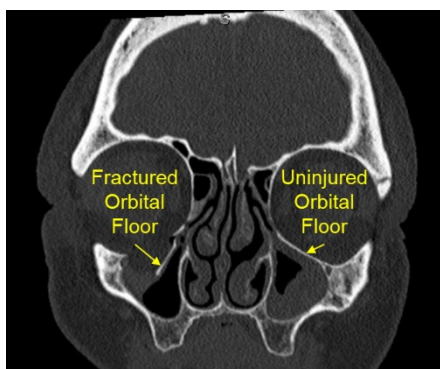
Maxillofacial CT scan of the patient showing fractured and uninjured orbital floors.
